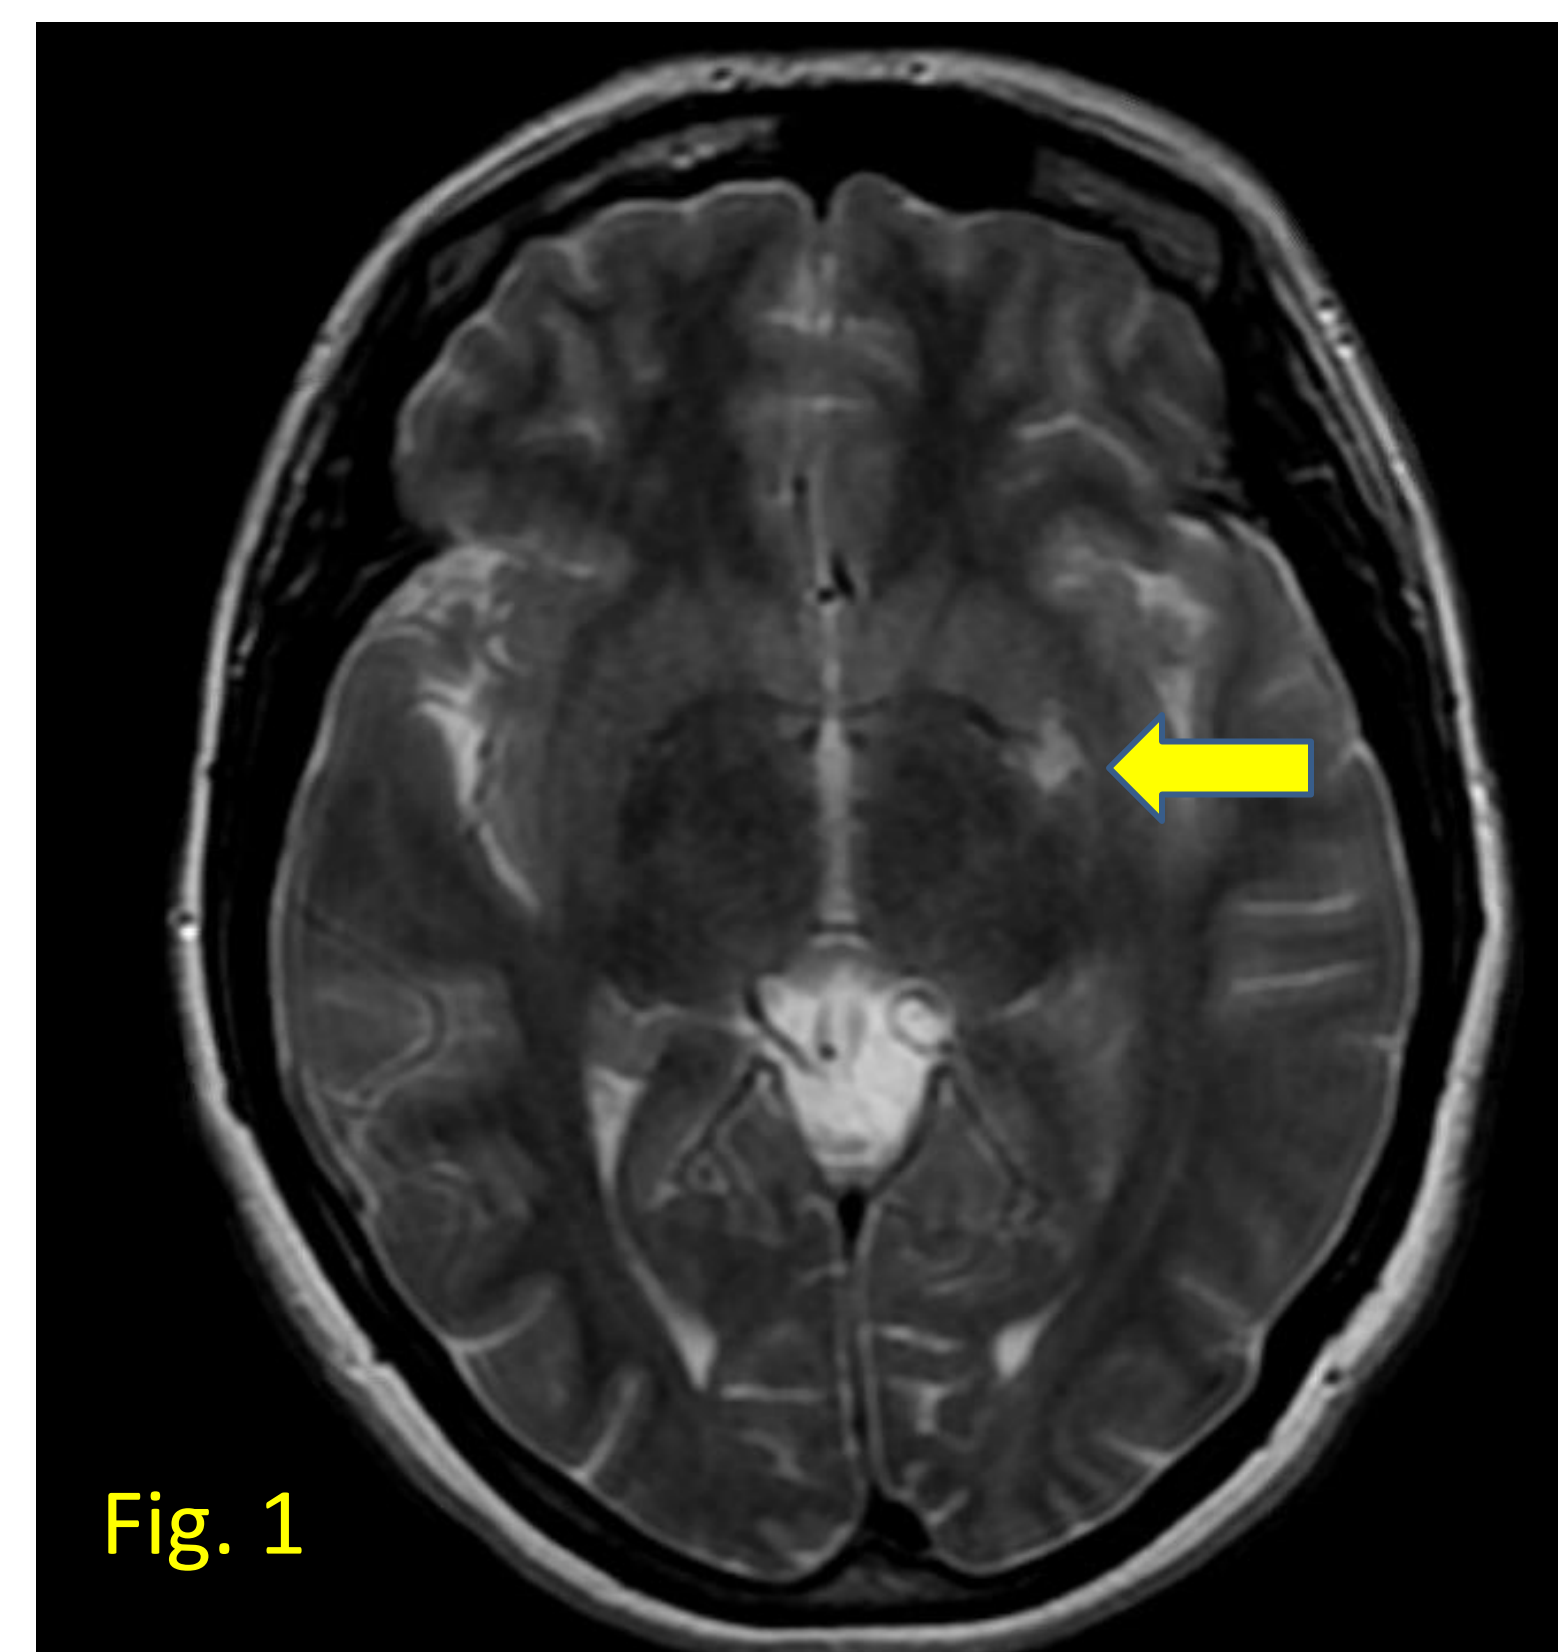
MRI of head significant for Acute infarction of the left-sided basal ganglia.
